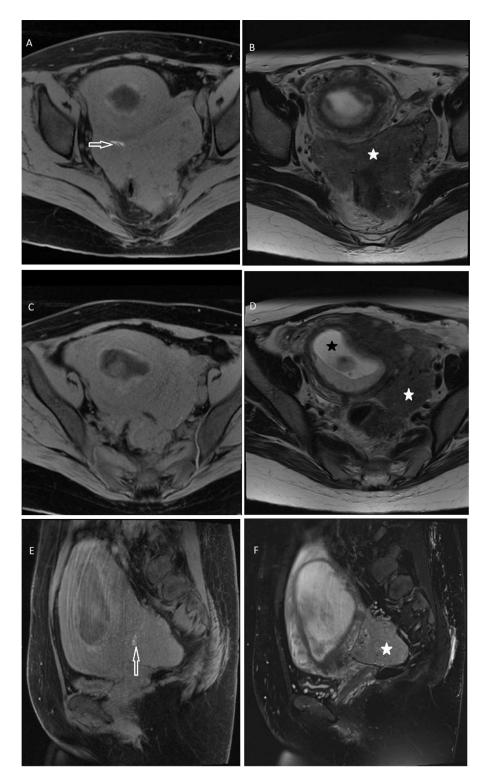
Pelvic MRI without contrast. (A and C) are axial T1 fat saturated images which are demonstrating large solid mass in the cul-de-sac with a few foci of T1 hyperintensity (white arrow) suggestive of active endometriosis disease. (E) is sagital T1 fat saturated image showing another view of the large pelvic mass abutting the posterior wall of the lower uterus and containing foci of T1 hyperintensity (white arrow) within the mass. (B and D) are axial T2 images anatomically corresponding to T1-weighted images and showing a solid mass (white star) abutting the uterus as well as the rectum with loss of fat planes between the mass and the rectum. The mass demonstrates T2 intermediate signal. Gestational sac (black star) visualized in the uterine cavity. (F) is sagital T2 image showing mass in the cul-de-sac with T2 intermediate signal and well-circumscribed margins.
